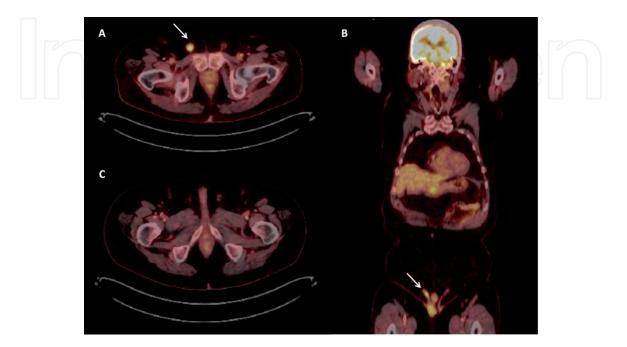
Burkitt's lymphoma relapse in the testicle. Radiotracer uptake is observed in the right inguinal canal (arrow, A and B). The last image (C) corresponds to the control PET/CT after right orchiectomy.
